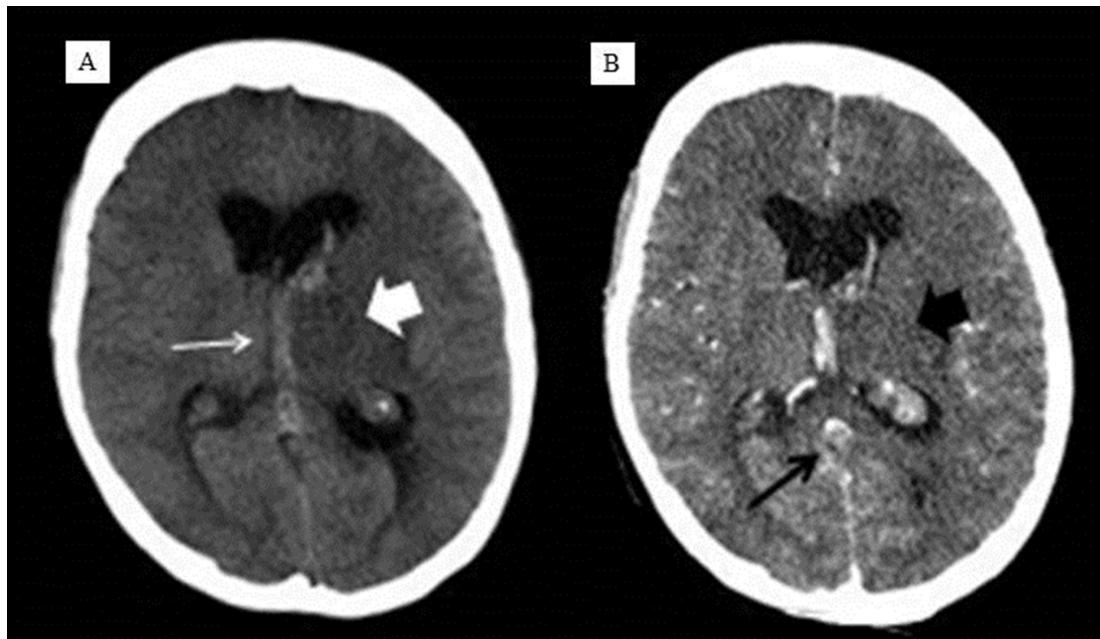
Images of the plain (A) and contrast enhanced (B) CT brain taken at the level of thalamus. The ill-defined hypodense lesion is seen at the left thalamic region (thick white arrow). The internal cerebral vein appears hyperdense and distended (thin white arrow). This hypodense lesion demonstrates no enhancement post contrast administration (thick black arrow). There is small filling defect noted within the distended great vein of Galen (thin black arrow).
